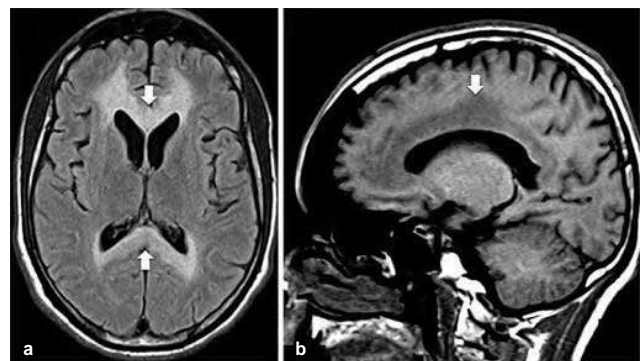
High signal intensity noted in axial FLAIR image with involvement of anterior and posterior portion of corpus callosum and periventricular white matter (a). Sagittal T1-weighted image with low signal intensity seen in entire length of corpus callosum shown with arrow (b).
